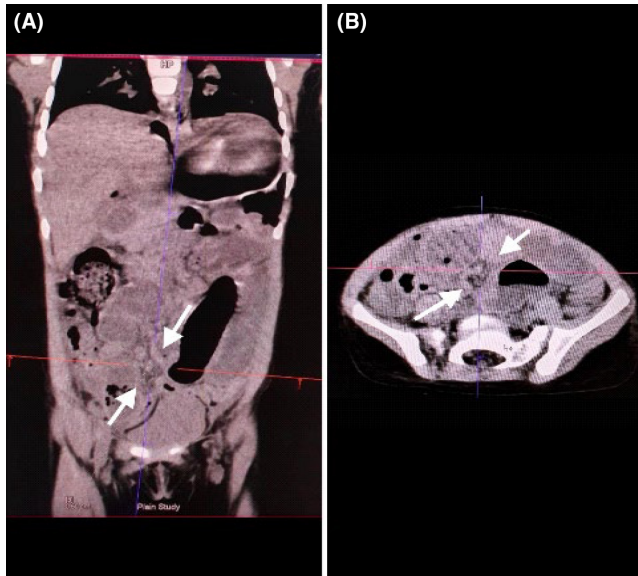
CT scan of the abdomen and pelvis in sagittal (A) and axial (B) planes showcasing inflammatory and peritoneal changes, with the appendix not visualized.
